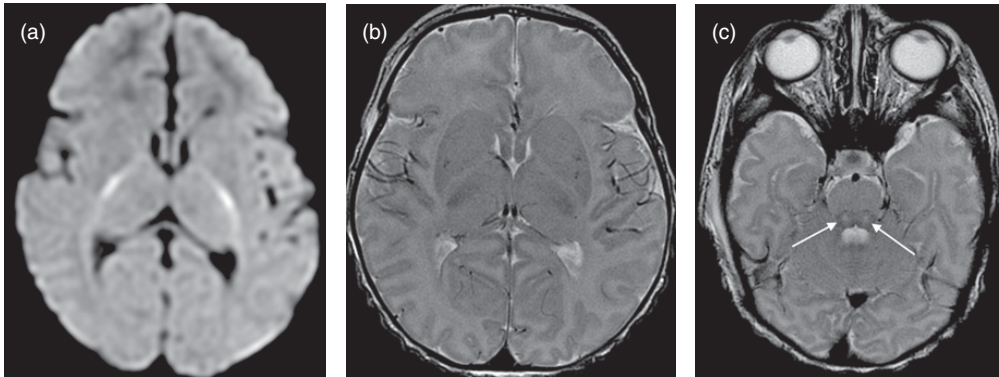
Non-ketotic hyperglycinemia in a newborn presenting with cardiomyopathy, hypotonia, myoclonic jerks, and burst suppression on EEG. (a) Axial diffusion-weighted imaging demonstrates diffusion restriction in the internal capsule and optic radiations. On T2-weighted imaging, there is (b) a corresponding lack of myelination of the posterior limb of the internal capsule and (c) an abnormal signal in the central tegmental tracts (arrows).
